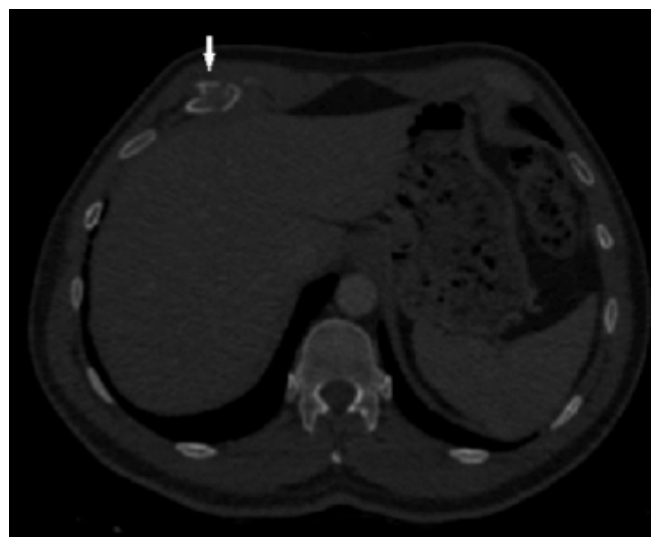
Axial reformation, mediastinal window of CT scan shows a lesion on the surface of rib. This lesion is radiolucent at partial places and in some regions calcification and lobules which have cartilaginous density can be seen. Note the asymmetry of bone and surrounding soft tissue relative to same rib level alignment of opposite sight. Calcification can be seen in the medullary cavities of lesion.
